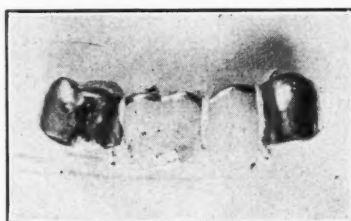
S. S., patient aged fifty years. Denture of 2 crowns and 2 teeth. In situ forty-eight hours. Lost by dentist during removal. Diagnosis made by x-ray examination, and the foreign body was located at the termination of the left main bronchus. There were no symptoms. Removed by bronchoscopy, under local anesthesia. Results: Patient cured.
